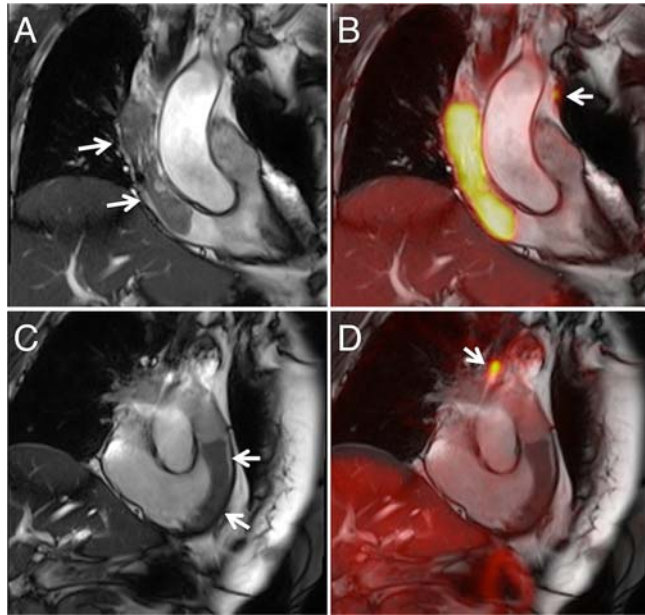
The first row (A and B) displays images of a patient with a history of breast cancer (Table 1, Patient 1), the second row (C and D) images of patient with anal cancer (Table 1, Patient 18). In both patients large intracavitary masses were initially found in echocardiography. The left column (A and C; arrows) shows SSFP images of large tubular masses in the superior vena cava and the right atrium (A) and in the right ventricular outflow tract (C). The right column (B and D) shows fusion images of SSFP and PET images clearly demonstrating malignancy in the patient with breast cancer (B) and a benign mass in the patient with anal cancer (D). However, closer inspection of the PET images revealed mediastinal lymph node metastases in both patients (B and D; arrows).
